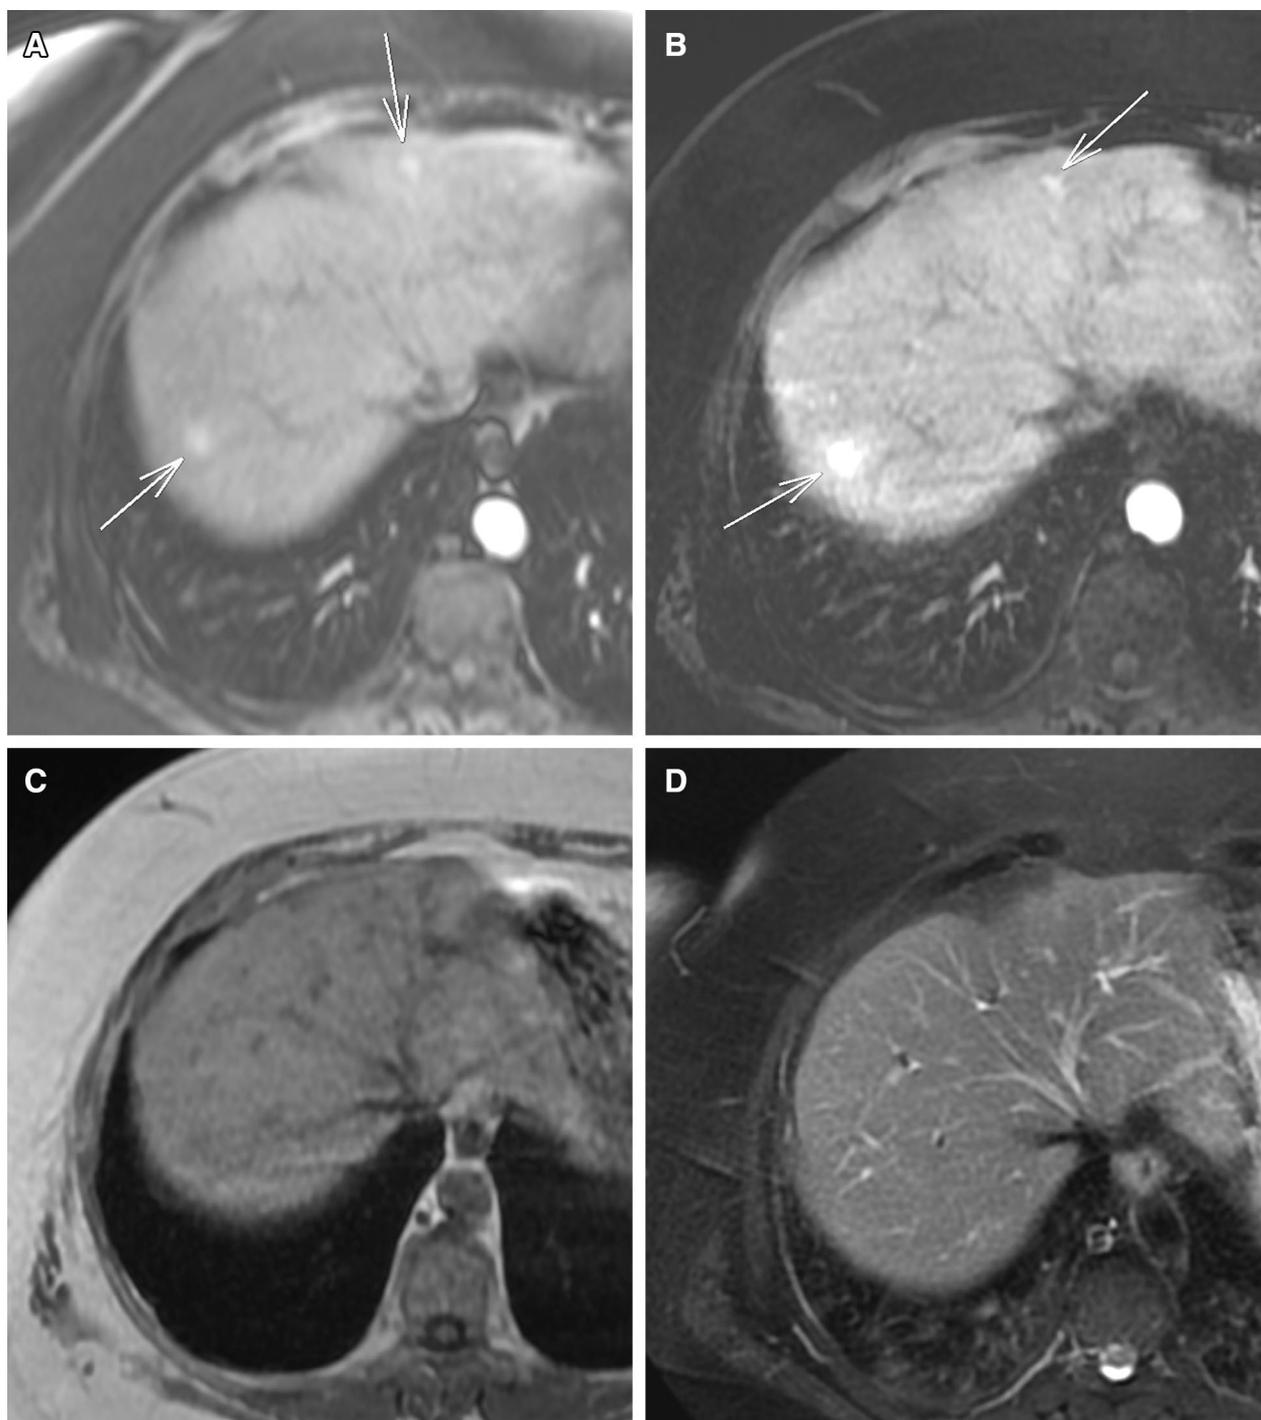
A Axial T1 post gadolinium images from an MRI in a 57-year-old woman after PDAC resection. Initial report impression stated “multiple enhancing mass lesions (arrows) noted in the liver. Findings are consistent with metastatic disease.” Second-opinion report stated “multiple arterially enhancing lesions throughout the hepatic
